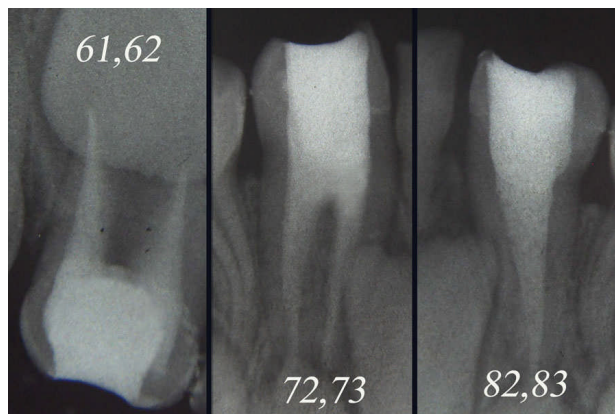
IOPA radiographs showing Endodontically treated fused teeth
